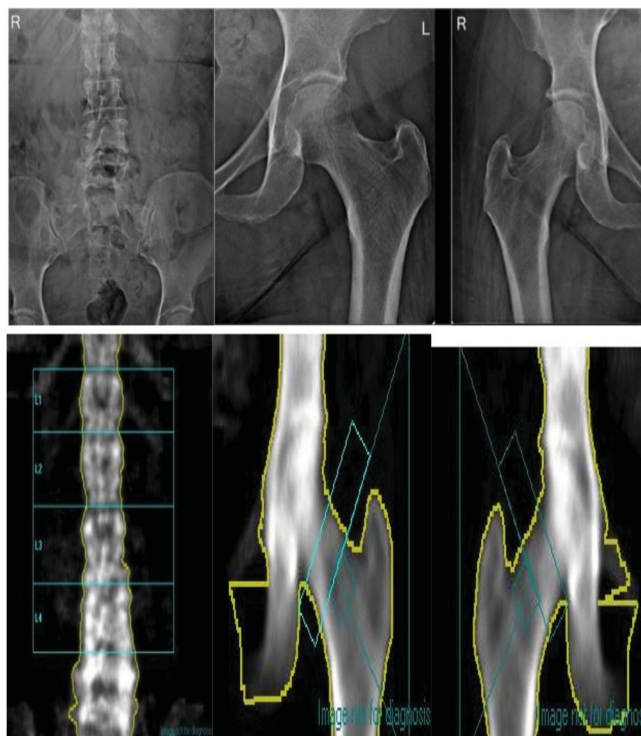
Sample picture of the same subject: X-ray images (top ) and DEXA images (bottom)
